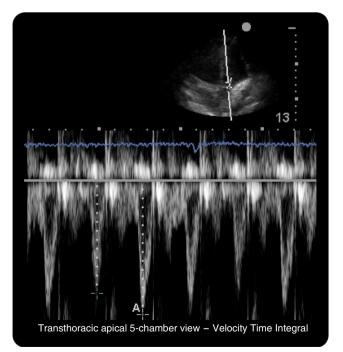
ECHO—transthoracic apical 5-chamber view with velocity time integral
